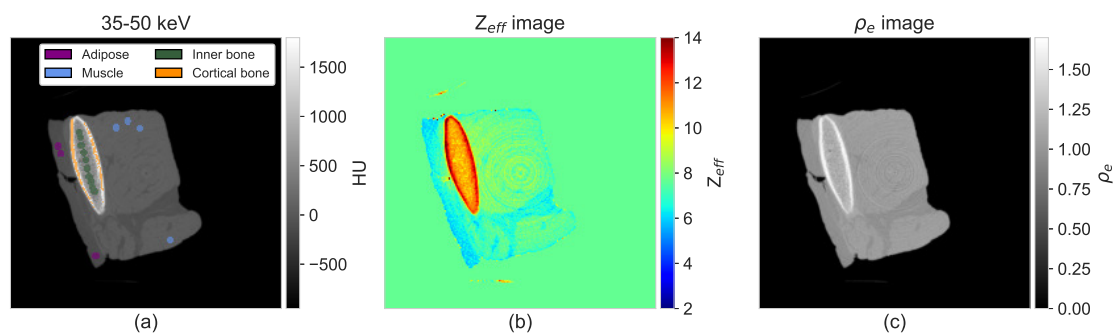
PCD-CT images of an *ex-vivo* tissue sample. (a) 35-50 keV CT image with the color-coded tissue-specific ROIs. (b) Effective atomic number image. (c) Relative electron density image.
